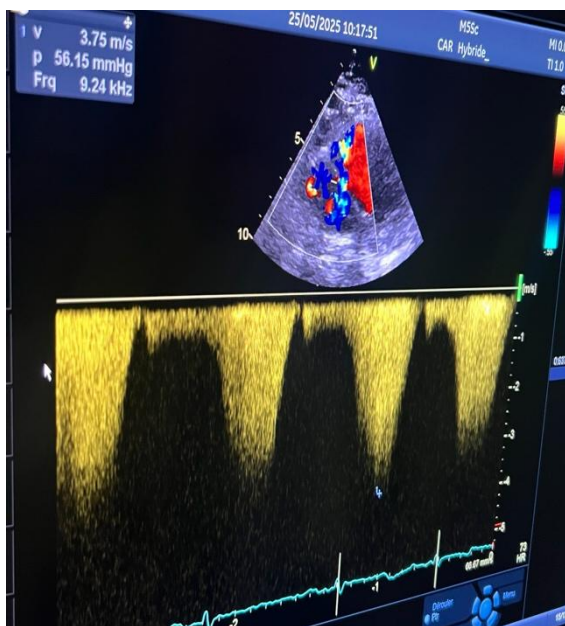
Transthoracic echocardiography with continuous-wave Doppler of tricuspid regurgitation showing a peak velocity of 3.75 m/s
